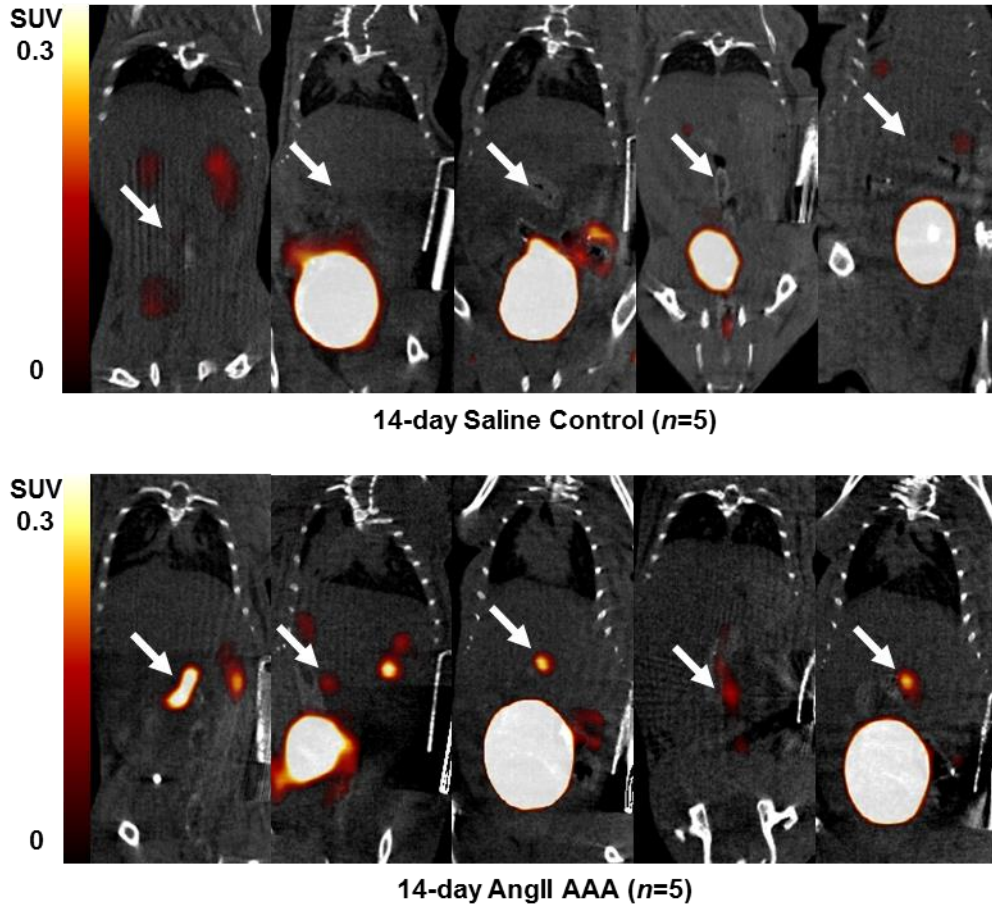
[^{18}F]FLT uptake in the abdominal aorta was greater in the 14-day AngII AAA model than in saline controls. Coronal-view PET/CT images of static 14-day abdominal aortic uptake of [^{18}F]FLT 80–90 min post-radiotracer injection in 14-day saline controls ($n=5$) and the 14-day AngII AAA model ($n=5$). Arrows indicate the abdominal aorta. Colour scale bars indicate SUV thresholding to aid visualisation.
